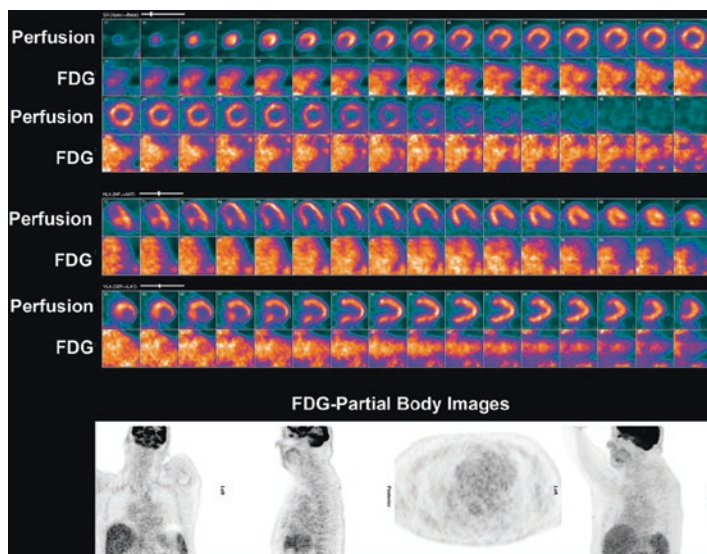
Evaluation of response to therapy. Repeat imaging of the patient from Fig. 10.1, after 6 months of high dose oral steroid showed near complete resolution of inflammation on FDG images (cardiac and partial body images show blood pool activity without focal myocardial uptake) with a small persistent region of fibrosis in the basal anterolateral wall (perfusion defect on the basal anterolateral wall). Quantitatively, there was no detectable inflamed myocardium (no pixels with $SUV > 2.7$). *FDG* ^{18}F -fluorodeoxyglucose
